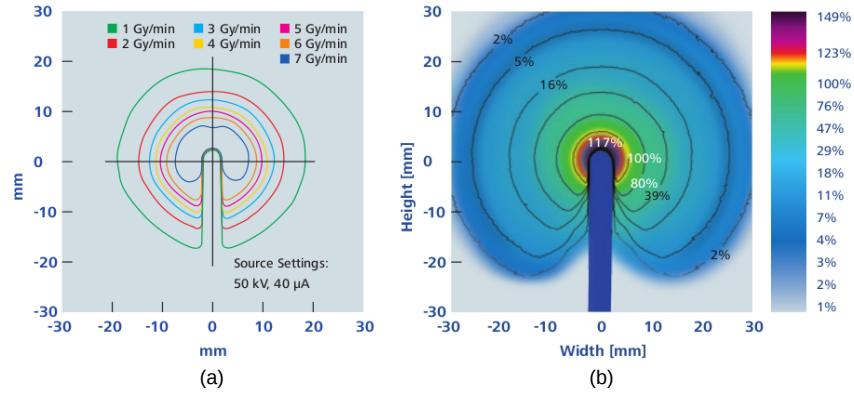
(a) Isodose contours of the Intrabeam[®] bare X-ray source. (b) Isodose contours of the Intrabeam[®] needle applicator (from Carl Zeiss Meditec AG)
